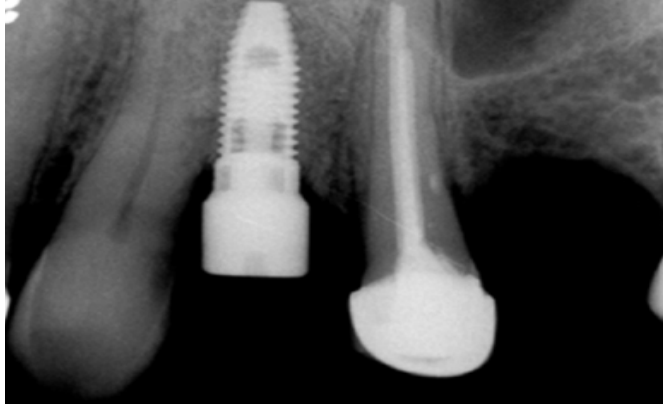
Xray of Implant and Root Canal Treated Tooth. Image retrieved from <https://www.osseonews.com/periapical-radiolucent-lesion-around-the-implant-diagnosis-and-treatment/>
